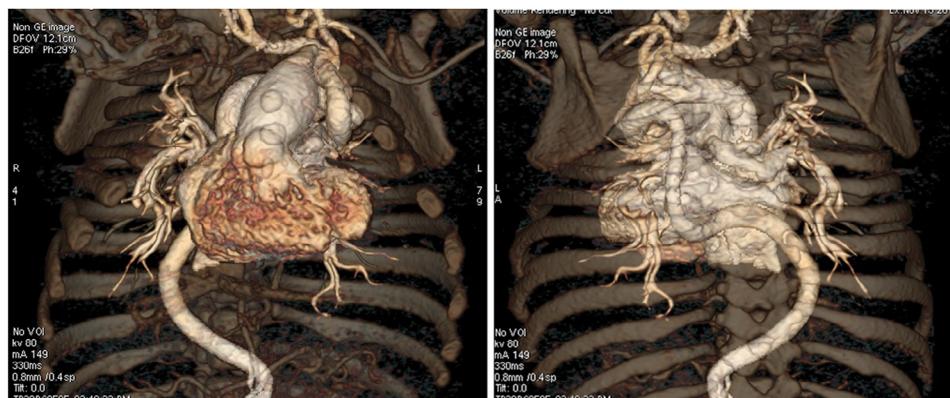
Anterior and posterior projections of the 3-dimensional reconstructions of the heart and vessels from computed tomography angiography congenital heart protocol obtained on day 1 of life demonstrate a marked tortuosity of the aorta, patent ductus arteriosus, and a dilation of the main pulmonary artery. DFOV, display field of view; GE, General Electric.
